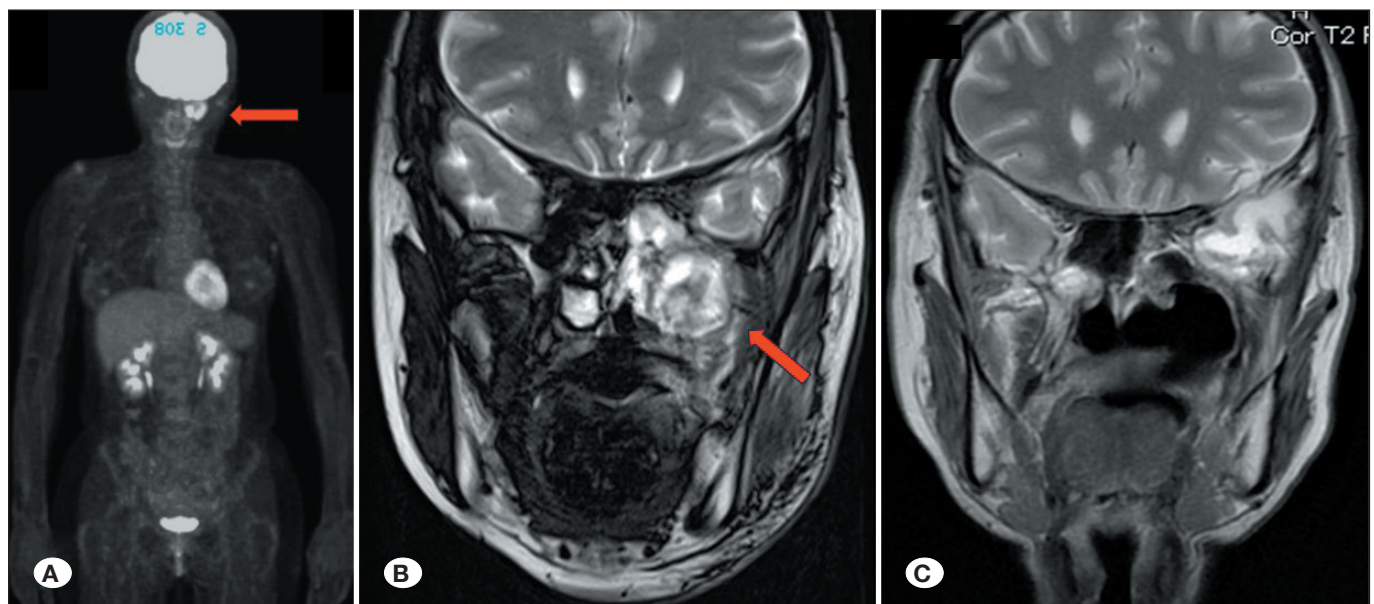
Left maxillary carcinoma recurrence (red arrows) observed in the positron emission tomography-computed tomography (A), and magnetic resonance image (MRI) (B), 9 years after initial removal. MRI showing suppression of the recurrent lesion after radiation therapy (C).
